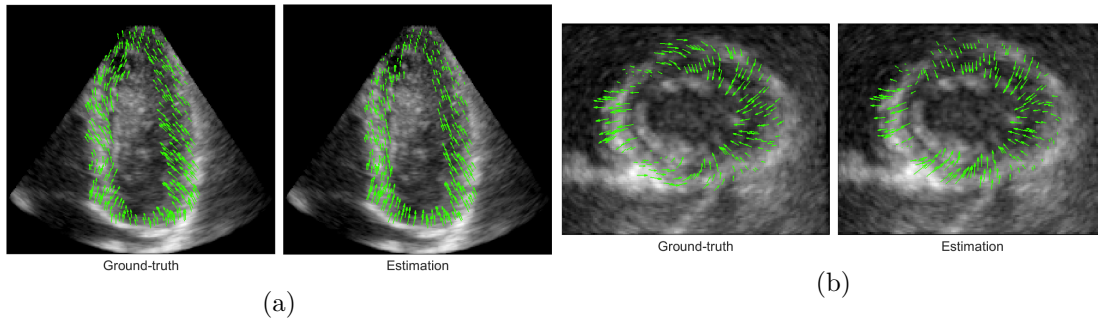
Ground-truth and estimated meshes of the 5th frame of the LADprox sequence: (a) apical four chambers view, (b) short axis view.
